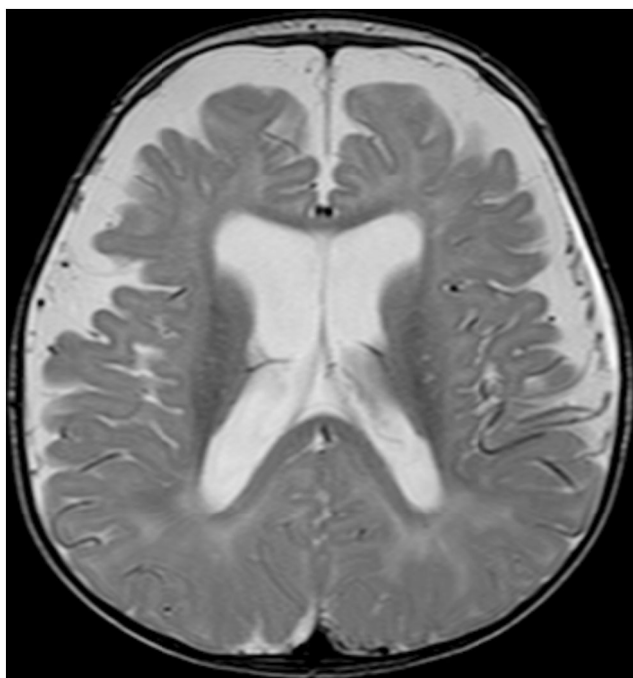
Ventriculomegaly and enlarged subarachnoid spaces in a 15-month-old boy with achondroplasia. Axial T2-weighted MR image (repetition time/echo time: 5,500/100 ms) shows the ventriculomegaly and prominent subarachnoid spaces in both frontal and parietal regions
